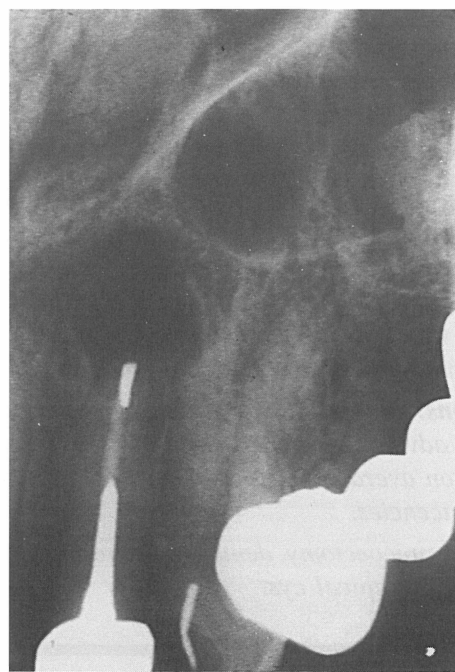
Ektaspeed® film intraoral radiograph of tooth with associated periapical radiolucency. Dimensions were estimated by direct measurement with the film placed on a viewbox in a room with subdued ambient lighting
